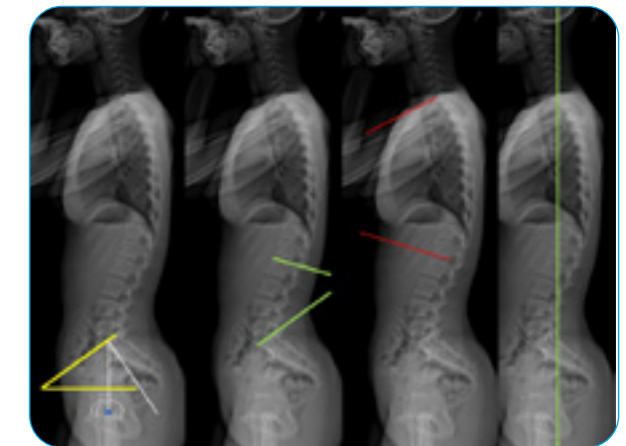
X-ray in the sagittal plane
